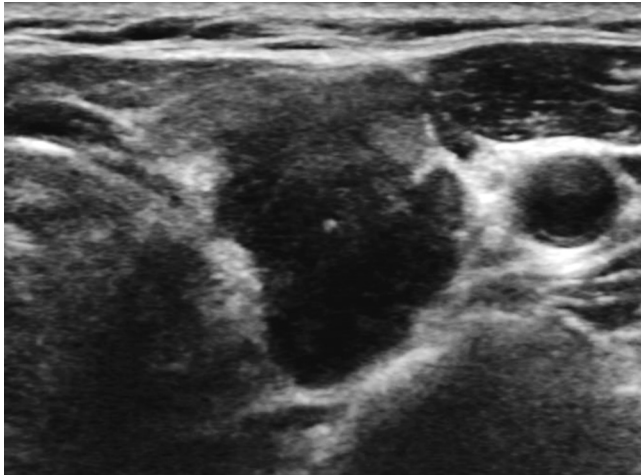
Ultrasonography feature of extrathyroidal extension of the thyroid cancer to the recurrent laryngeal nerve. Protrusion of thyroid cancer into the tracheoesophageal groove. Diagnosis: gross extrathyroidal extension to the recurrent laryngeal nerve. Adapted from Chung et al. Korean J Radiol 2020;21:1187-1195 [129].
